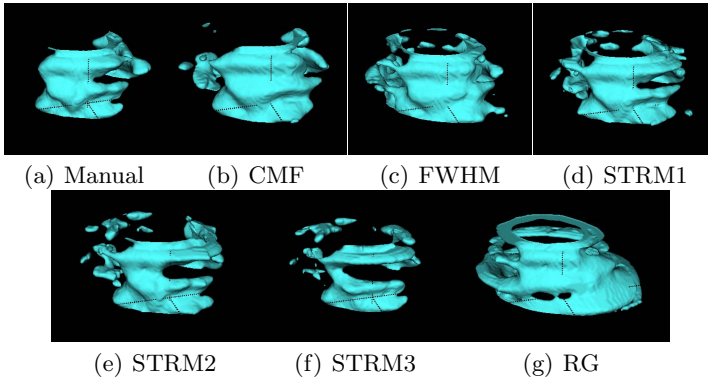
Comparison of the infarct surfaces generated using each method for one 2D LGE-MR image
